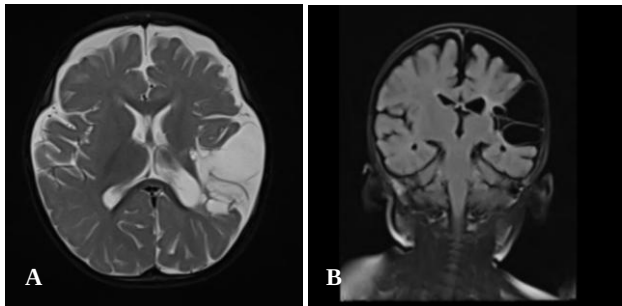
(A) Axial T2-weighted image showing a large cystic encephalomalacic cavity involving the left frontoparietal region with surrounding gliosis, diffuse left cerebral hemispheric volume loss, and ex vacuo dilatation of the left ventricle, consistent with chronic cerebral infarction and (B) coronal FLAIR image demonstrating extensive left frontoparietal cortico-subcortical encephalomalacia with associated left cerebral hemispheric atrophy, corresponding to chronic cerebral infarction.
